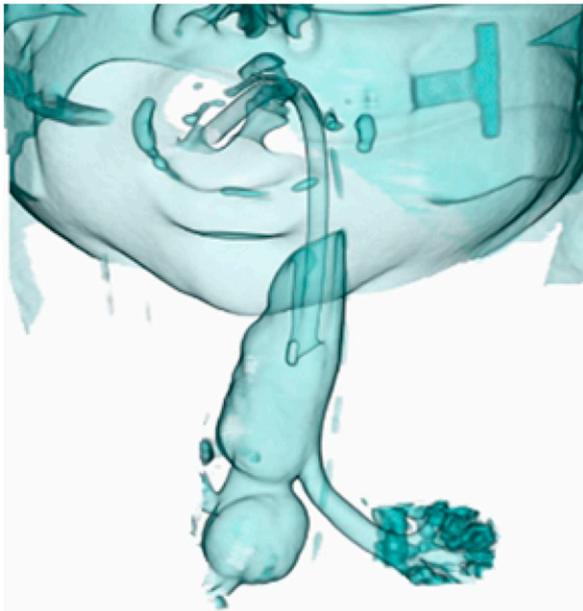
Coronal reconstructions from the same computed tomography study show massive dilation of trachea and right mainstem bronchus correlating well with the lucent lesion visualized on prior imaging. Three-dimensional surface rendering of the trachea and airway demonstrates massive dilation of the trachea and right mainstem bronchus.
